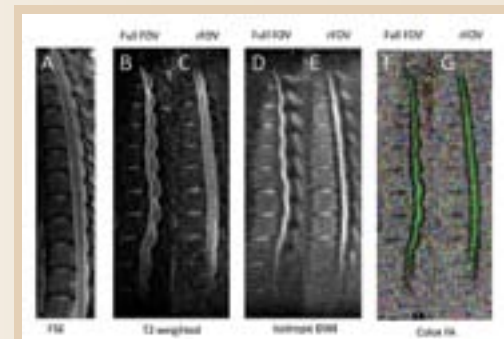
Thoracic spine images compared. The FSE (a) is shown for anatomical reference. The full FOV T2-weighted image (b) has much more distortion than the rFOV image (c). The DWI (d,e) and color FA (f,g) images show a similar effect.
